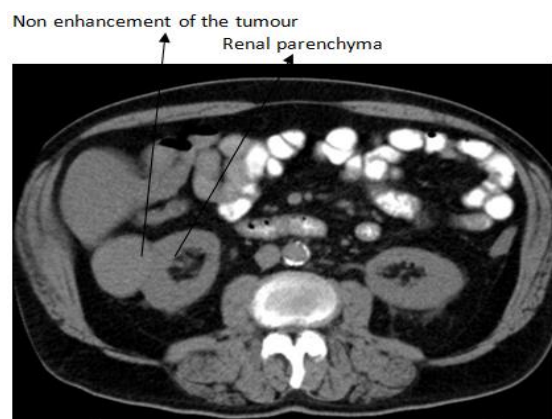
CT shows a 5 cm right renal mass lesion isodense to renal parenchyma. Weak contrast enhancement from 40 to 50 HU on the average.
